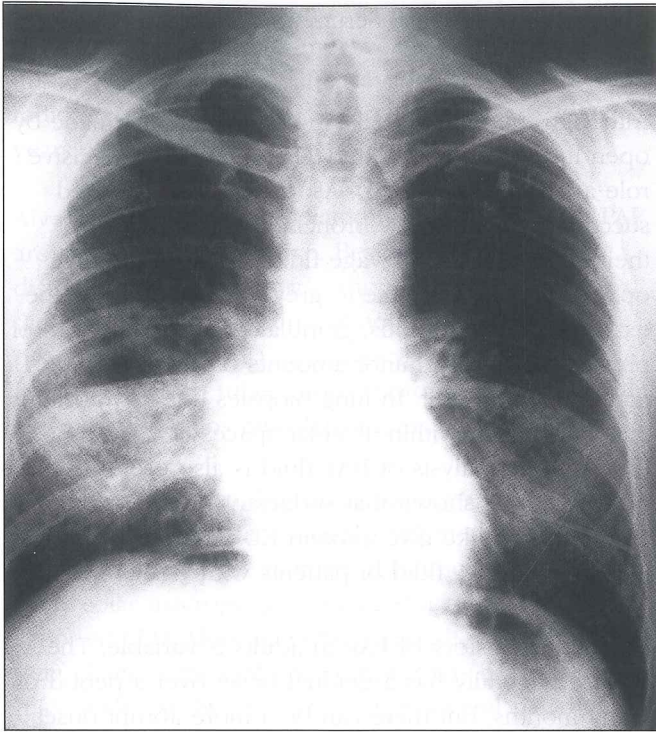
Chest X-ray at admission showing bilateral infiltrations.
